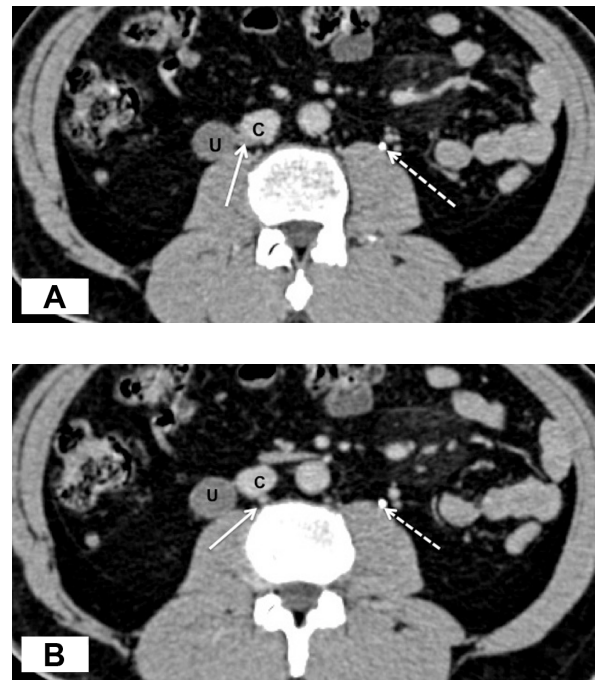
Contrast-enhanced computed tomography scan in the axial view showing (A) the dilated right ureter (U) proximal to its obstruction. The ureter follows a medial course at this level (solid arrow), posterior to the inferior vena cava (C). At a lower scan (B), the retrocaval location of the right ureter is medial compared with the normal location of the left ureter (dashed arrow).
